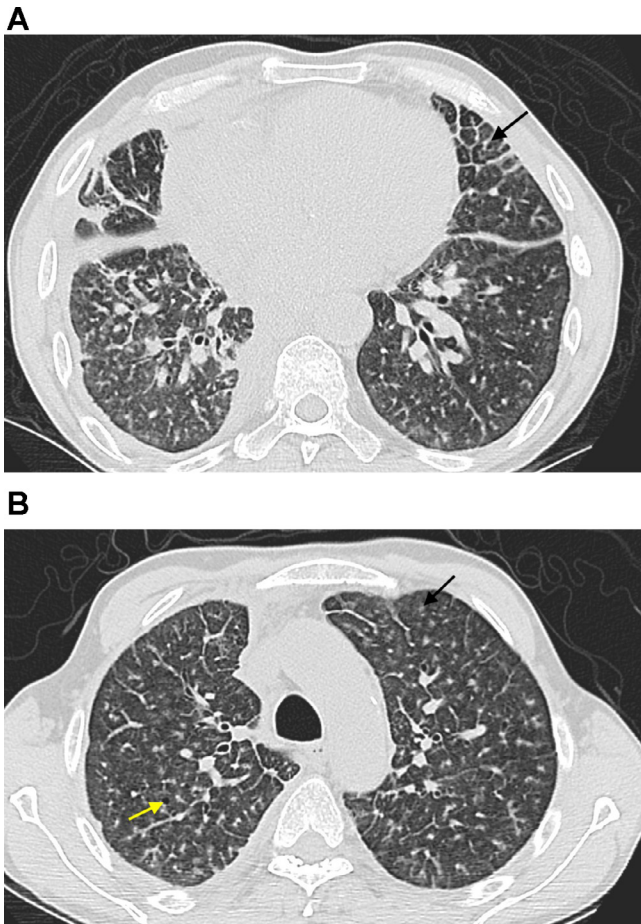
A 53-year-old male patient with Erdheim Chester disease. Thoracic CT scan in parenchymal window showing: (A) smooth and regular septal thickening (yellow arrow). (B) Centrilobular micronodules (black arrow) and small air-filled cystic formations (yellow arrow).
